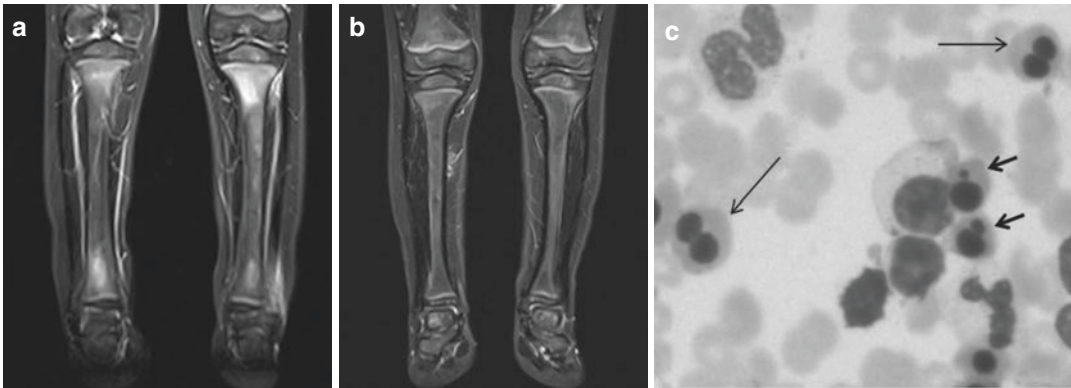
Clinical findings in Majeed syndrome. (a) Increased signal intensity on MRI STIR sequences primarily located in the metaphyseal regions of the long bones in a child with Majeed syndrome. (b) Resolution of abnormal STIR signal 3 months following initiation of an
